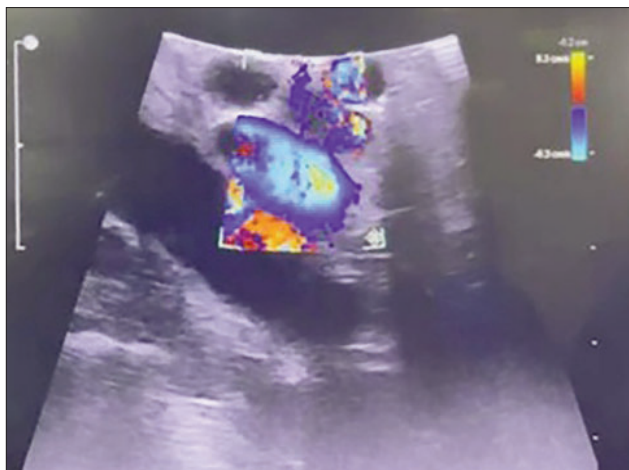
Doppler function to distinguish the portal vein and hepatic artery from the common bile duct. The portal vein and hepatic artery (which exhibit flow, blue coloration) were readily distinguished from the common bile duct, which lacks internal flow.
